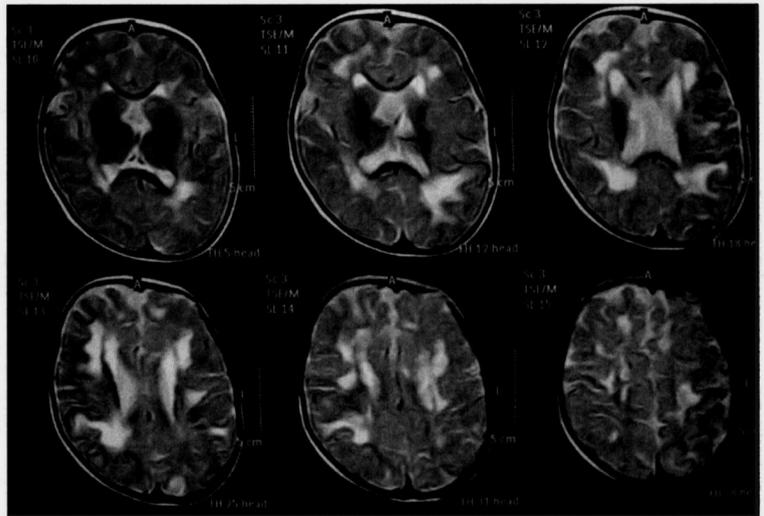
MRI of patient 2: T2W axial cuts showing hyperintense signal of the white matter in the periventricular region especially around frontal and occipital horns indicating white matter demyelination. Note the patchy, irregular shape of demyelination
